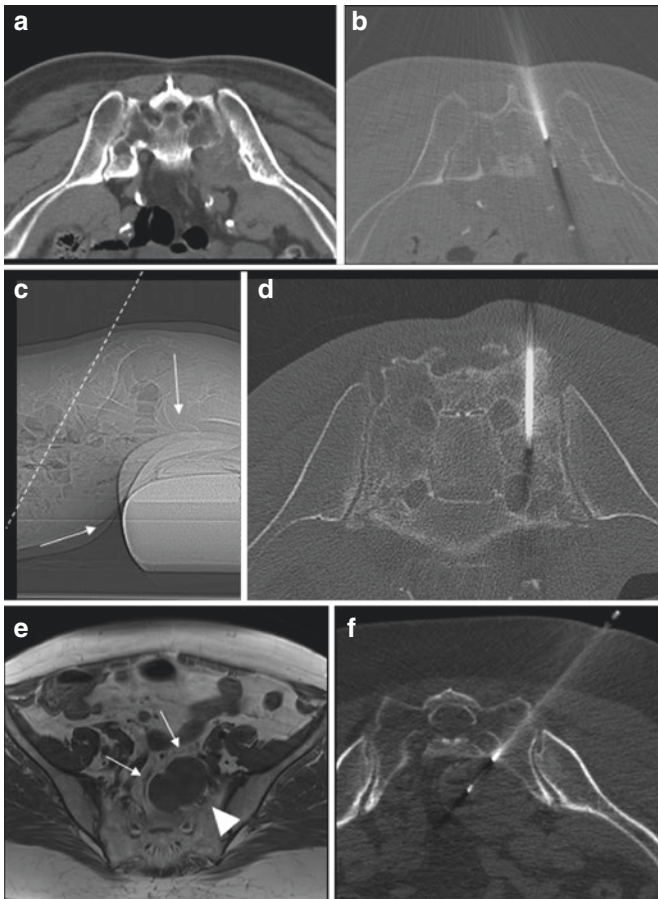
CT-guided sacral biopsies: (a, b) a lytic lesion of the sacral wing, eroding the contours of the neuroforamen biopsied through a short-axis access, just lateral to the expectable border of the sacral foramen. (c, d) Extensive permeative lytic and sclerotic changes of the sacral wing, biopsied through a long-axis access. A bolster placed under the hips (arrows on c) serves to render the sacrum more vertical, so that the gantry tilt can reproduce the obliquity of the sacrum long axis. (e, f) Trans-sacral approach to biopsy a presacral mass (arrows on e); the access was planned to spare the sciatic nerve coursing just ventral to the sacrum (arrowhead on e); a cutting spring-loaded biopsy needle was used coaxially to sample this soft tissue lesion
